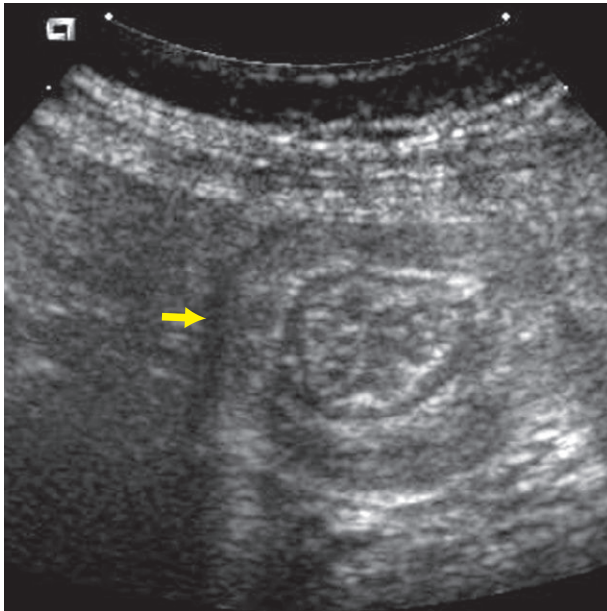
Transverse ultrasound of structure on RLQ of the abdomen in area of pain. Demonstrates target appearances of intussusception (arrow).
